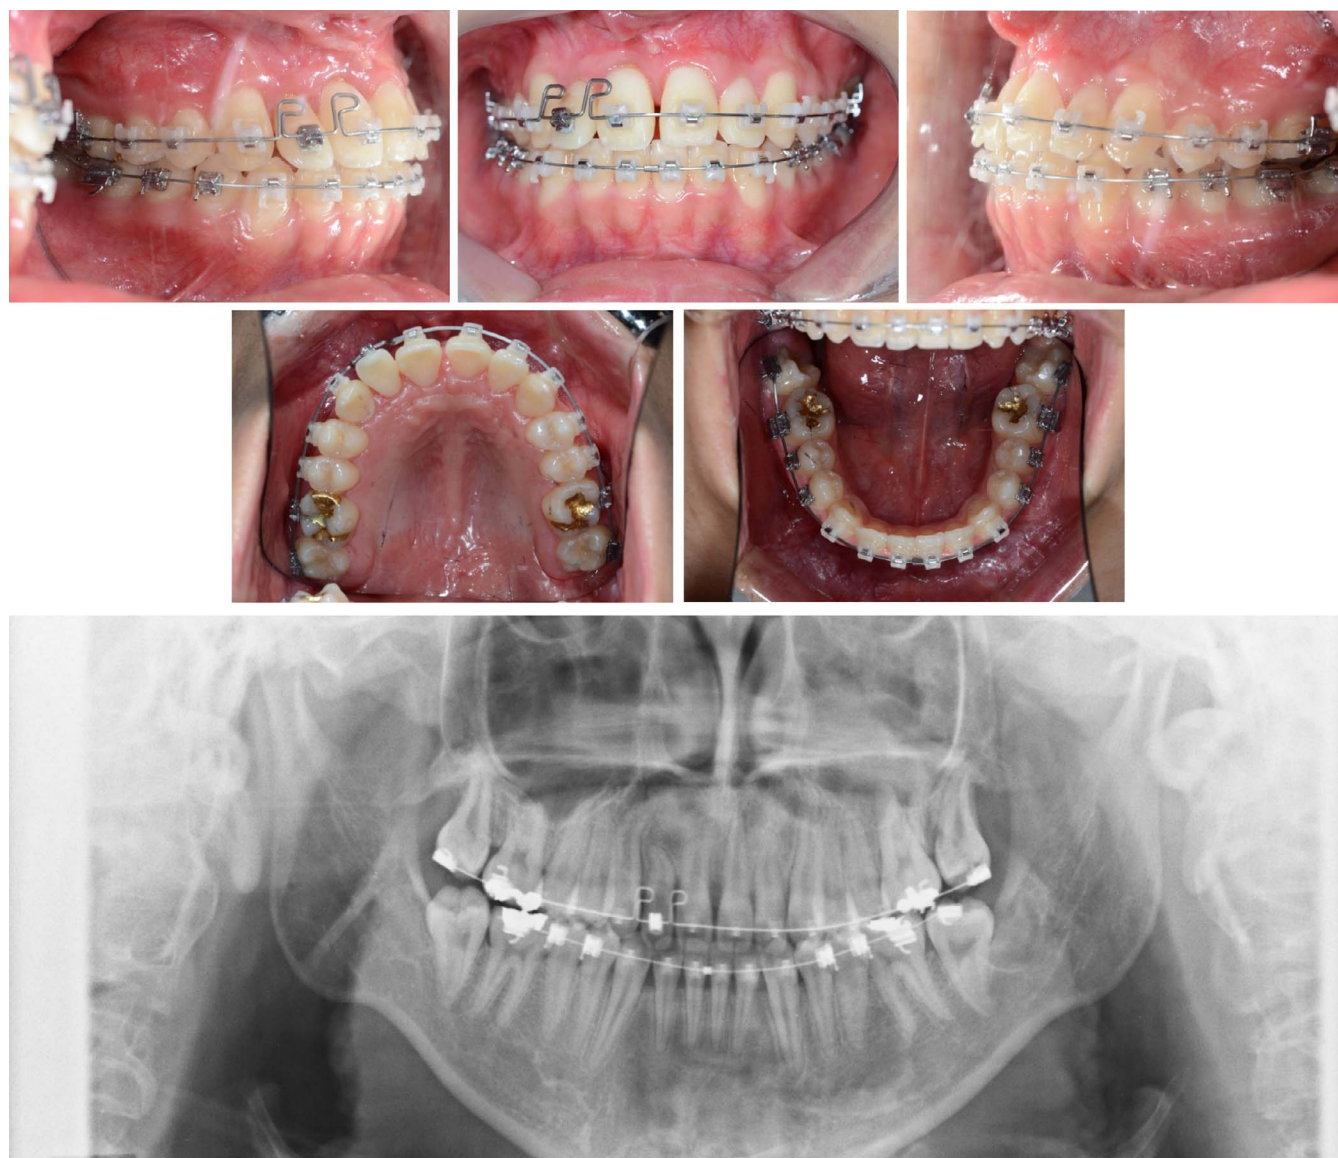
Intraoral photos and panoramic radiograph at 40 months of treatment.
